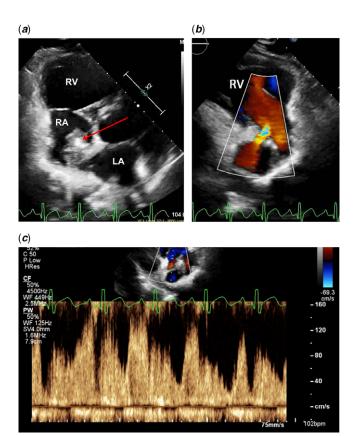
(a) Echocardiogram (parasternal short-axis view) depicting a large broadbased thrombus (red arrow) adherent to the right atrial (RA) side of the venous baffle with mural thrombus on the left atrial (LA) side 5 months from the initial surgery. RV=right ventricle. (b) Echocardiogram (parasternal long-axis view) demonstrating colour flow acceleration in the systemic venous pathway in the right atrium. RV=right ventricle. (c) Pulsed-wave spectral Doppler profile of the systemic baffle obstruction in the right atrium.
